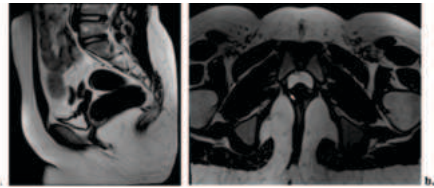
T2W sagittal (a) and axial (b) MRI sequences demonstrating a hypoplastic uterus
